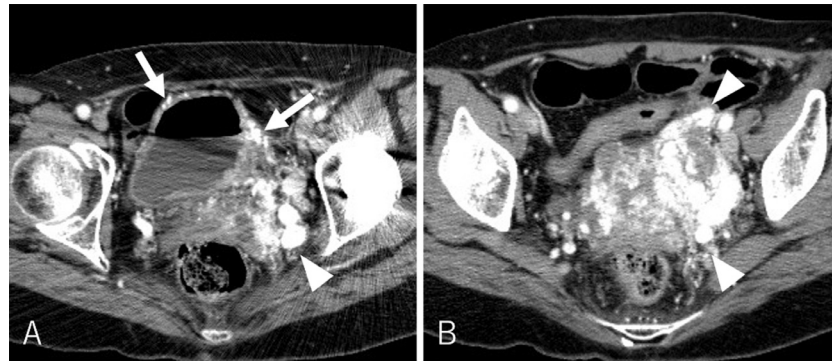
Axial contrast-enhanced CT images of the original lesion. There was a huge hypervascular lesion in the retroperitoneum and the pelvis, which involved the wall of the urinary bladder (A, arrows). There was no bone involvement. Note the dilated LIIV and LOV (A, B, arrowheads).
